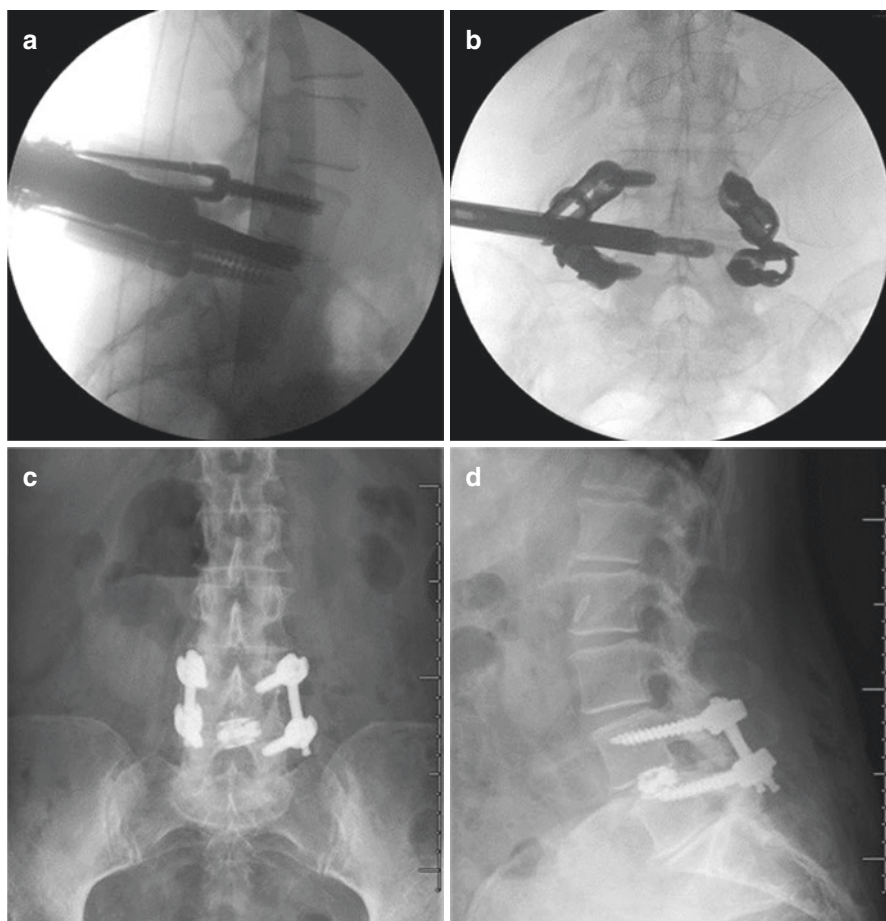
Endoscopic transforaminal lumbar interbody fusion. (a) Intraoperative lateral fluoroscopy of transforaminal placed introducer at the anterior boundary of the L4–5 disk space. (b) Intraoperative anterior posterior fluoroscopy of transforaminal place tunneller with interbody being deployed, crossing midline. (c) Postoperative anterior posterior plain film displaying percutaneous placed pedicle screws and rods at L4–5 with an expanded interbody. (d) Postoperative lateral plain film showing instrumentation and correction of spondylolisthesis while standing
